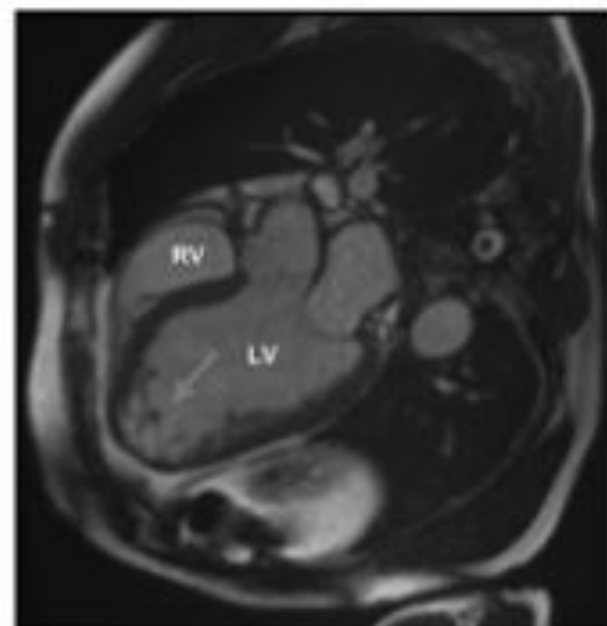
MRI of the heart confirmed the diagnosis of noncompaction cardiomyopathy, excessive trabeculation (arrow) LV = left ventricle, RV = right ventricle
